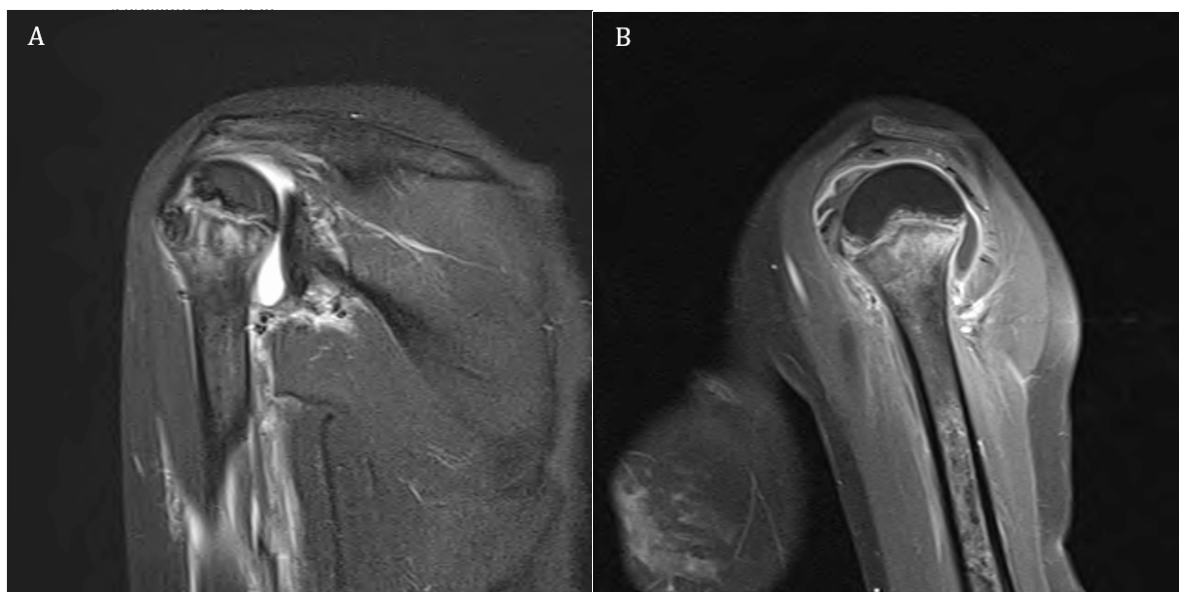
MRI imaging obtained during the first episode of infection; A) coronal STIR of the right shoulder demonstrating high T2 signal in the humeral metaphysis with an associated joint effusion; B) sagittal post-contrast T1 fat-saturated image demonstrating enhancement in the humeral metaphysis and synovial enhancement. Patchy enhancement and signal dropout in the humeral diaphysis is caused by treatment-related bone infarction.
